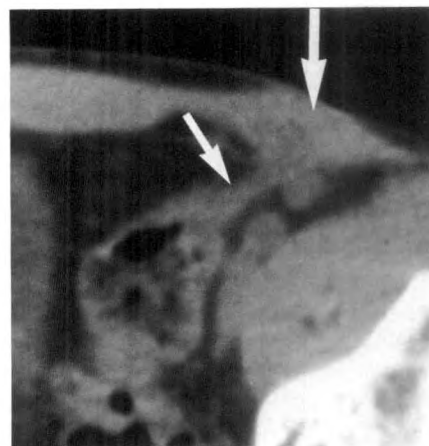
25-year-old man with abdominal pain and palpable area of fullness in left lower quadrant. Clinical impression was possible enterocutaneous fistula. Barium enema and upper gastrointestinal small-bowel follow-through did not show fistula. CT shows fistula from sigmoid colon into anterior abdominal wall with inflammatory mass present (arrows).
